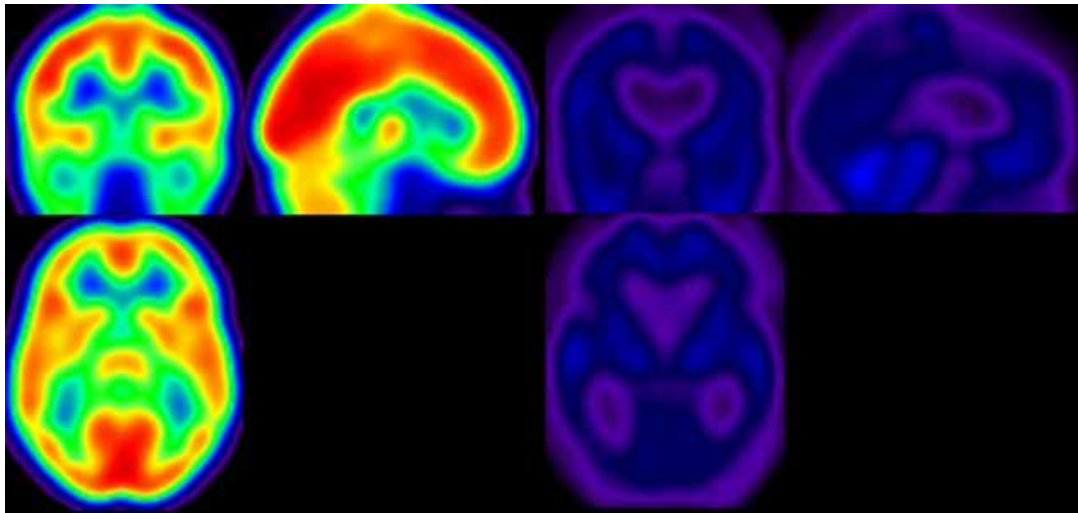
Global brain metabolism detected by FDG-PET in a healthy control (left) and in a patient in an unresponsive wakefulness syndrome (right). Red colorscale indicates regions with high consumption of glucose; blue colorscale indicates regions with low consumption of glucose.
